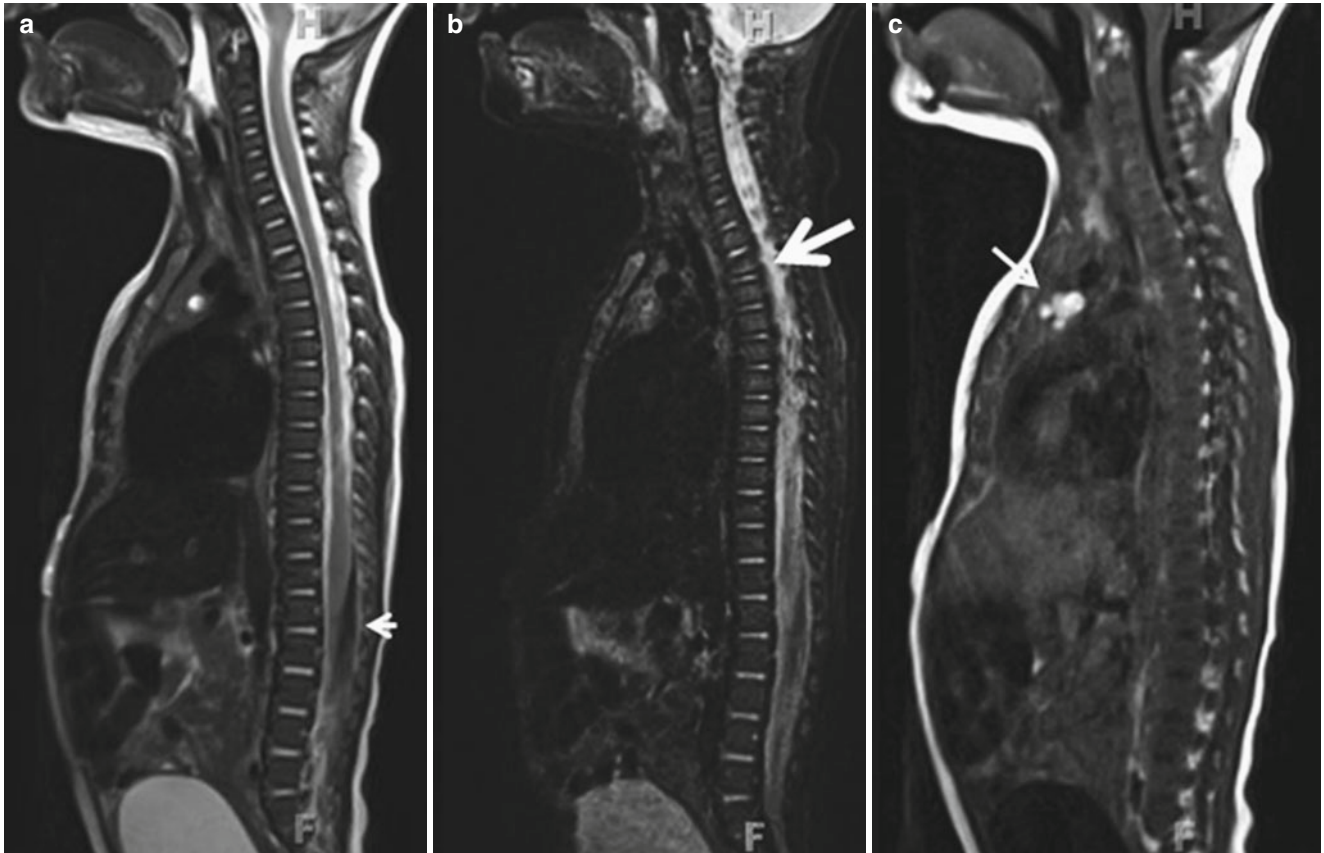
Sagittal midline T2-weighted MR image (a) shows an epidural hematoma in the posterior lumbar spinal canal (white arrow head). The sagittal STIR image (b) reveals a compression fracture at the level T2
